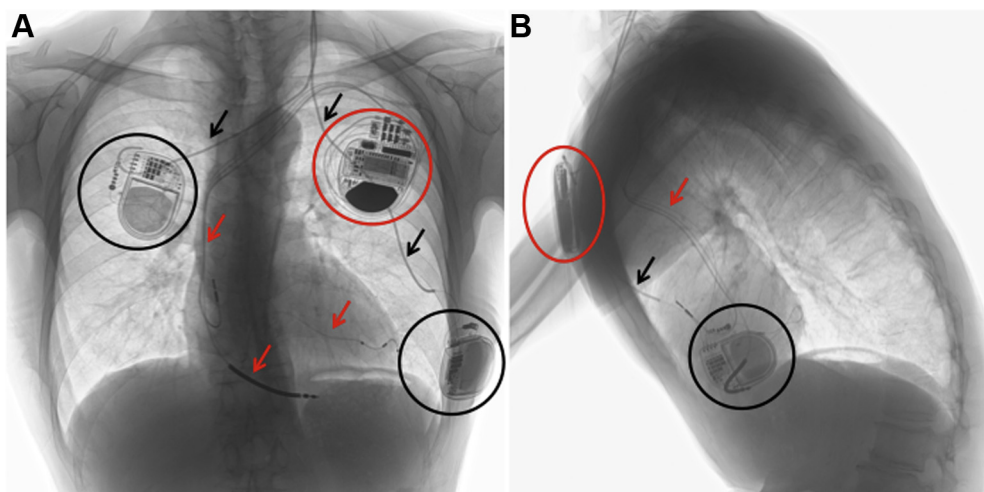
Postoperative frontal (A) and lateral (B) radiographs showing the leads of the cardiac resynchronization therapy–defibrillator (CRT-D) (black arrows), leads of the neurostimulation devices (NSDs) (black circles), pulse generator of the NSDs (red arrows), and pulse generator of the CRT-D (red circles).
